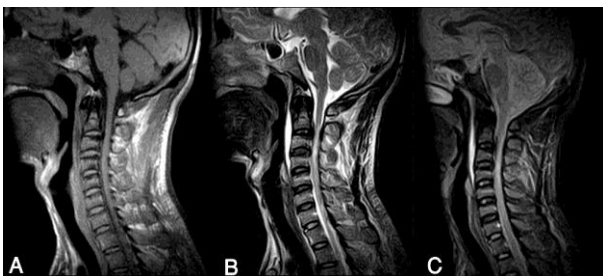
MRI cervical T1, T2 and FLAIR sagittal images showing calcified posterior longitudinal ligament behind C2-3-disc space with cord compression and cord signal changes.
